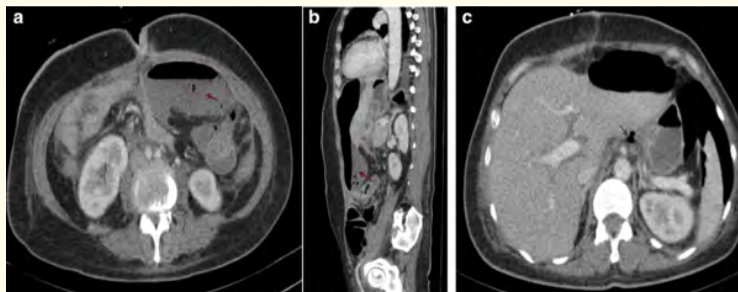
(a, b) Axial and sagittal view on a contrast-enhanced CT scan, showing a voluminous fluid collection in the peritoneal cavity, in contact with the jejunocolic anastomosis extending from the diaphragm to the umbilicus (red arrow). (c) Axial view on a contrast-enhanced CT scan, indicating a bubble of pneumoperitoneum near the gastro-duodenal anastomosis (green arrow).
